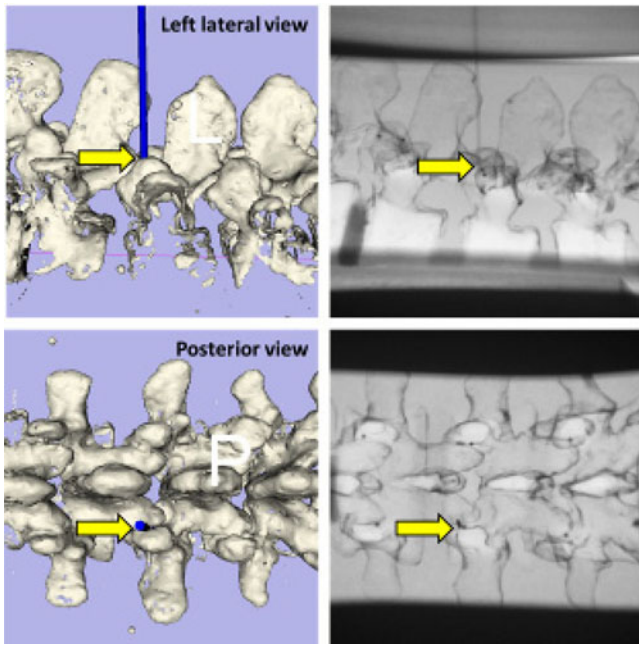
Interpretation of needle position in the synthetic human spine model is assisted using bone surface model from the registered CT volume of the model (left side). Orthogonal fluoroscopic images (right side) were used as an independent verification method for needle tip position. Arrows points at the needle tips.
